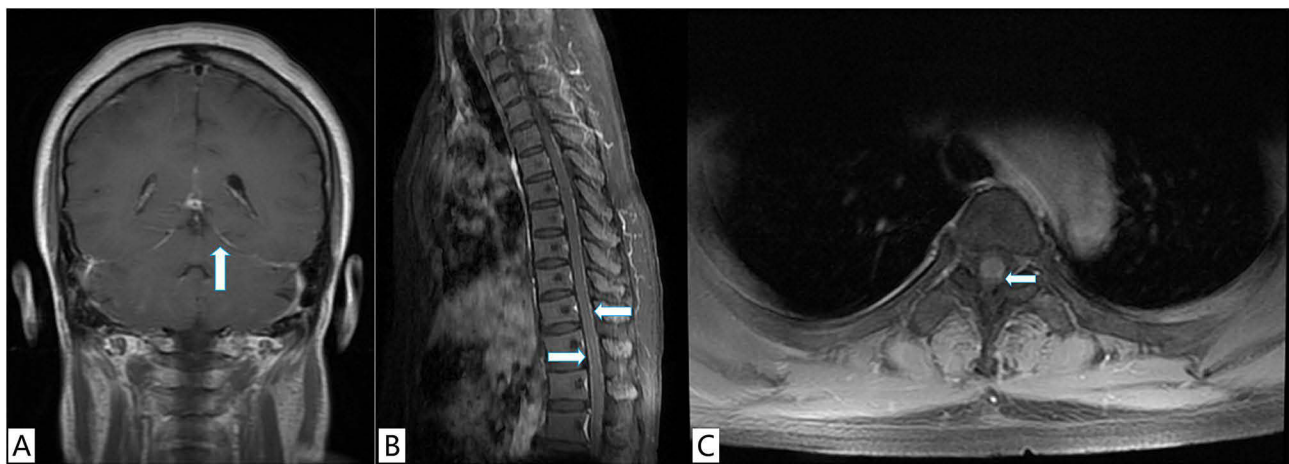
Contrast-enhanced MRI images of patient #4, a female, 44 years old, with headache, fever, dysuria, bilateral weakness, and numbness in four limbs. (A) Brain MRI image showing the enhancement of signal at pia mater (arrow); (B) Sagittal spinal MRI image showing strip-like enhancement of signal at thoracic pia mater (bold arrow) and intramedullary piece of enhancement of signal (arrow); (C) Axial thoracic contrast-enhanced MRI showing enhancement of signal at thoracic pia mater (arrow).
